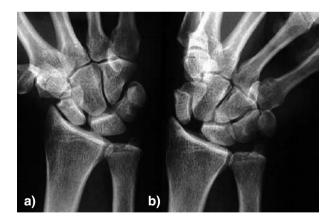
(X-ray PA view in neutral position and ulnar deviation of the carpus. a) normal scapholunate articulation maintained; b) scapholunate dissociation
